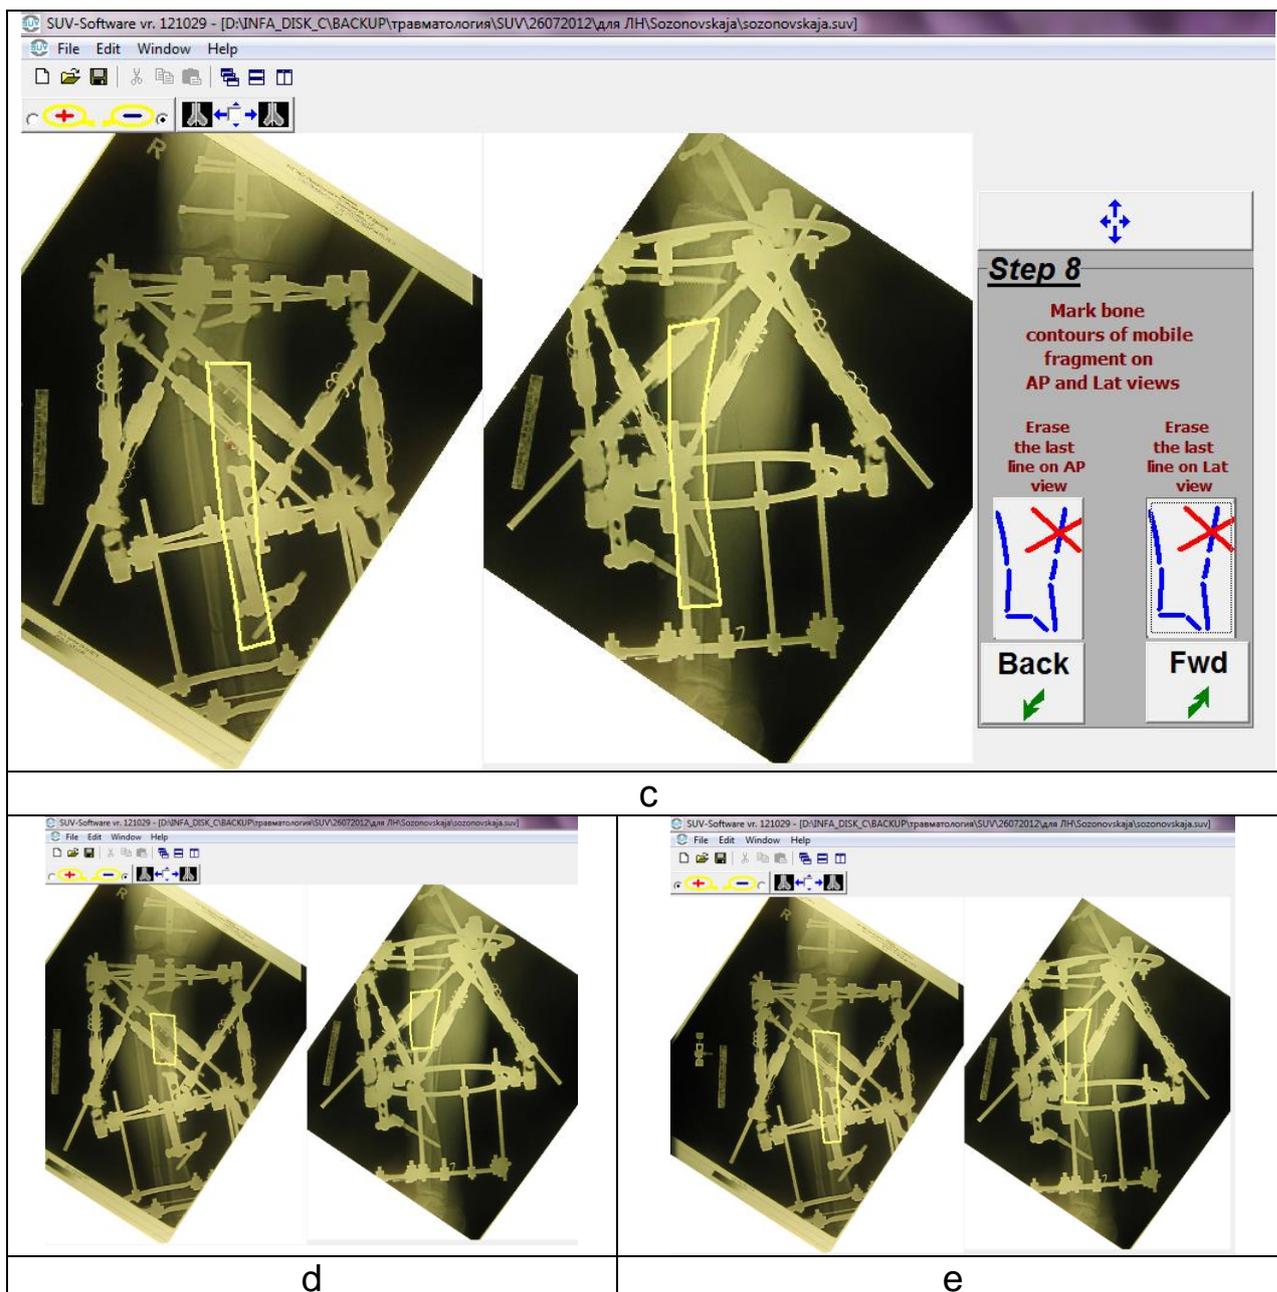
Ortho-SUV software window in Step 8. a – arrow points the button of moving of fields of roentgenograms. On AP view arrow indicates the yellow point made by cursor. b – yellow line in projection of cortex of distal fragment (AP view) is drawn. c – yellow bone contours on AP and Lat view are done. Note that bone contours are of equal length. d, e - possible variants of bone contours of mobile fragment
